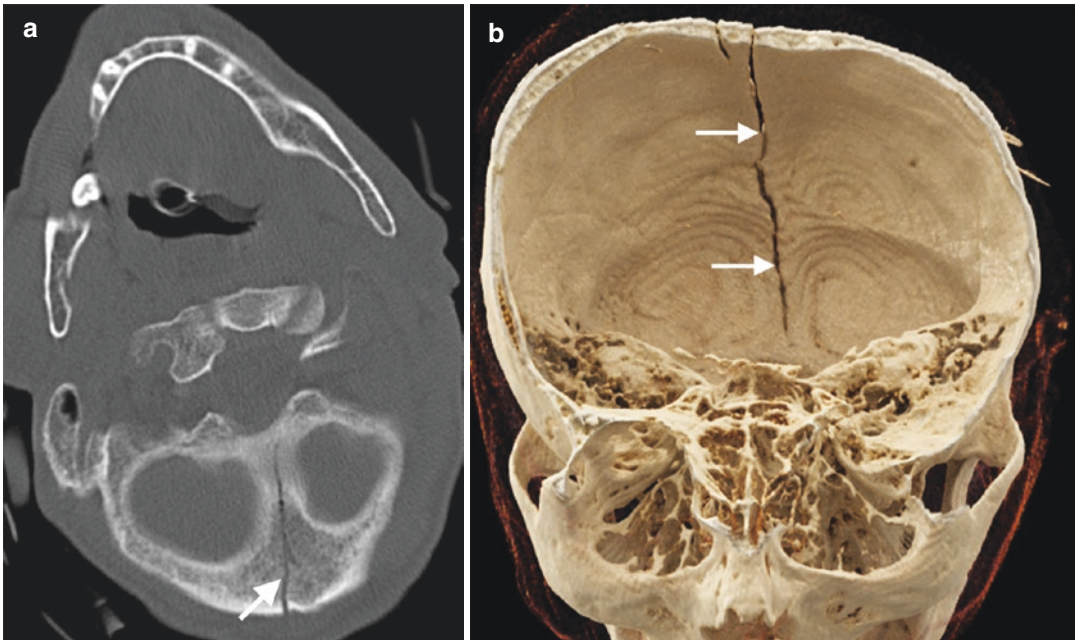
Occipital bone fracture involving PSB. (a) Axial CT image demonstrates a linear fracture (arrow) extending from squamosal part of occipital bone through basilar part. (b) Superoinferior view of CR image shows fracture (arrows) involving squamous and basilar parts of occipital bone
